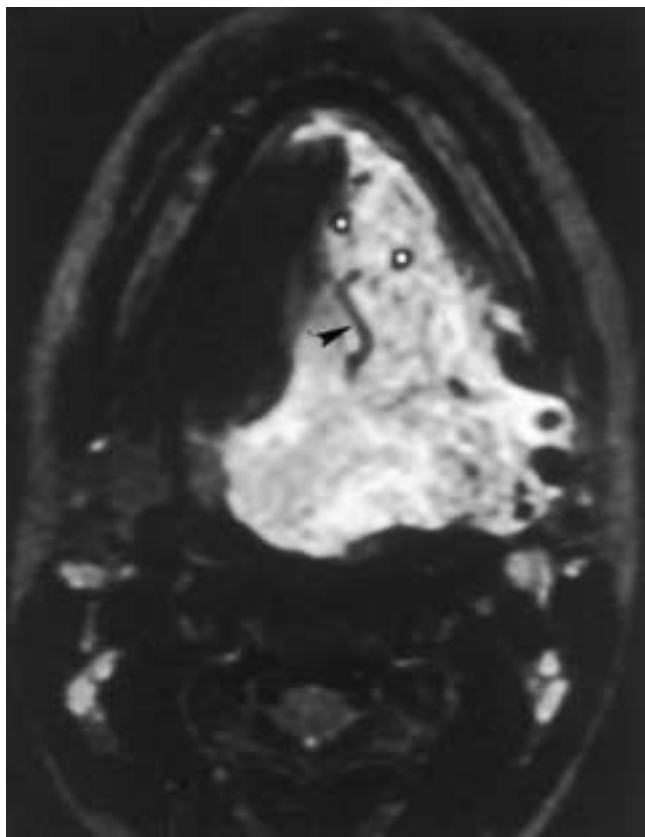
Combined vascular malformation. Axial proton density MR image demonstrates a large, invasive vascular malformation possessing features consistent with both arterial and venous components. Vessels are seen as serpiginous signal voids (*arrowhead*). Circular signal voids (*white dots*) may represent vessels or phleboliths. A large, solid mass component demonstrates high signal intensity and marked heterogeneity involving the left half of the tongue, crossing the midline. (Courtesy of Dr. Edward Kassel.)
